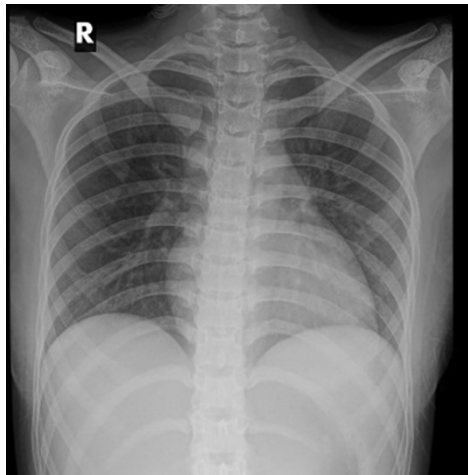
Chest X-ray was unremarkable
